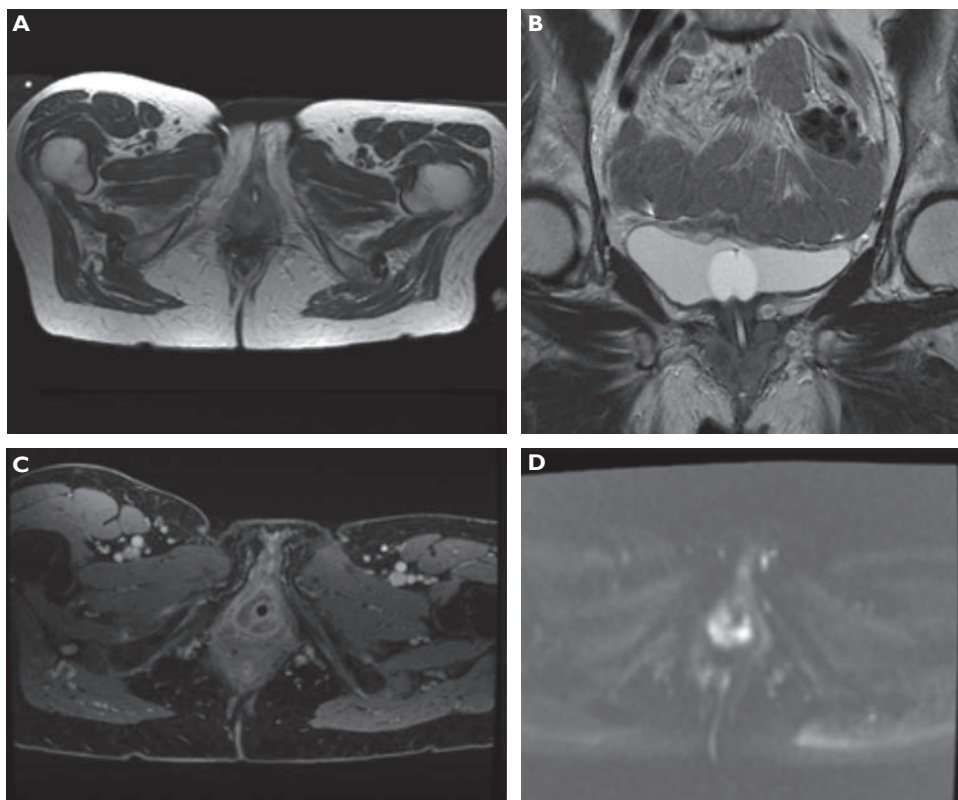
Magnetic resonance imaging sequences: A) axial T2; B) coronal T2; C) axial T1 fat-suppressed performed after contrasting medium administration; D) axial DWI (diffusion-weighted imaging) at high b-values. Examination revealed an increase in the size of the known vaginal lesion; there were no substantial variations of the intensity-contrastographic characteristics and the infiltrative appearance on the urethral meatus and the levator ani muscles.
